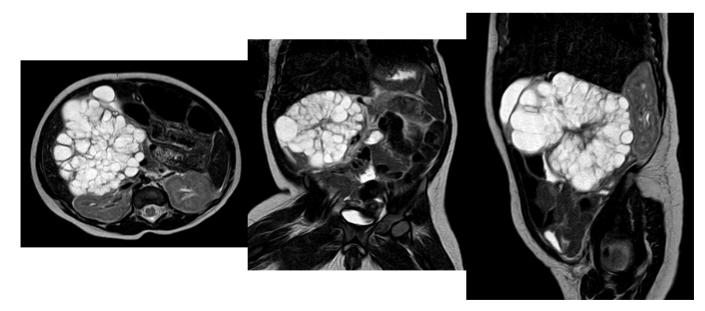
2. Abdominal MRI, T2 weighted images. Axial (A), coronal (B) and sagittal (C) views. They show a well-delimited hyperintense multicystic mass with anteroposterior diameter of 62 mm, longitudinal 59 mm and transverse 64 mm. In the center there is a hypointense solid stellate area. It produces compression of the inferior vena cava, renal vein and right kidney. No pancreatic head is seen in any of the sections.
